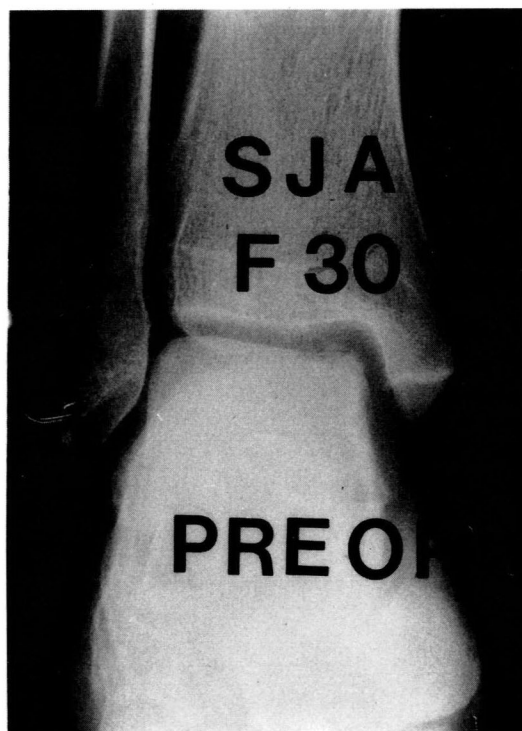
Simple X-ray showed osteochondral fragment on the talar dome without displacement.
